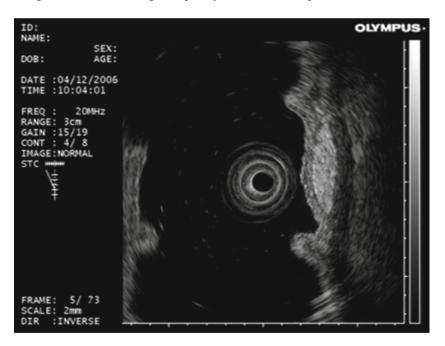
Endosonographic imaging demonstrates an ovoid, hyperechoic, homogeneous mass in the third echolayer (submucosa) of the gastric antrum. The appearance is typical for a small lipoma.
